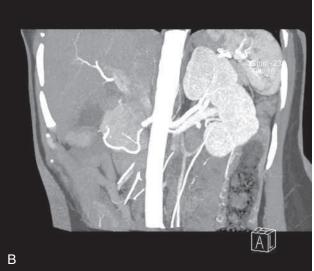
Living donor preoperative computed tomographic angiogram. (A) Three-dimensional reconstruction of arterial supply. Note the lower pole artery to the right kidney (arrow), which may supply the ureter as well as the lower pole parenchyma. (B) Conventional image showing single artery and vein to the left kidney.
